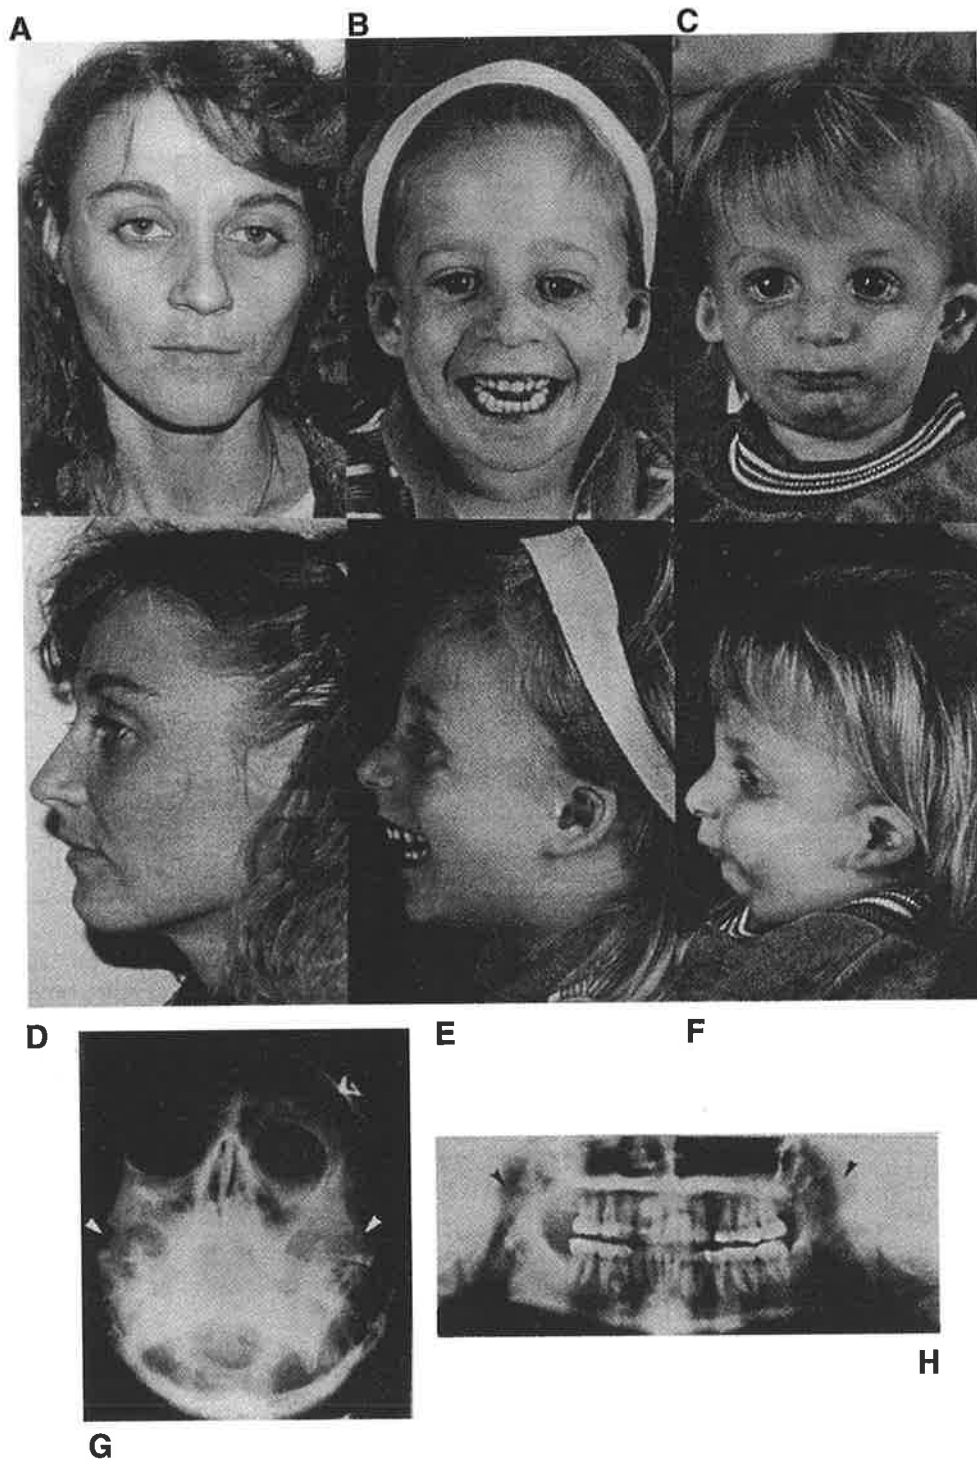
Photographs of family A.-F. and radiographs showing absence of zygomatic arches (arrowed) in mother, II.6 G. and H.
